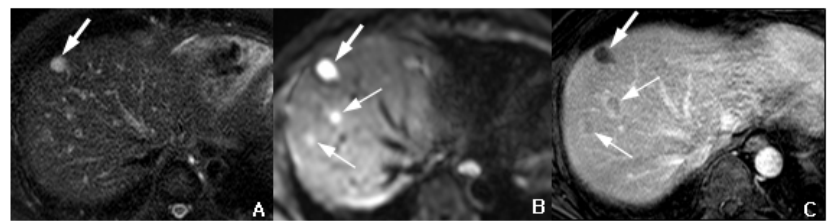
52-year-old man with hepatic metastases from stomach cancer. Small sized metastatic masses in right hepatic lobes (thin arrows) are identified on diffusion-weighted image (B) and portal-phase enhanced image (C) but not visualized on T2-weighted image (A).
